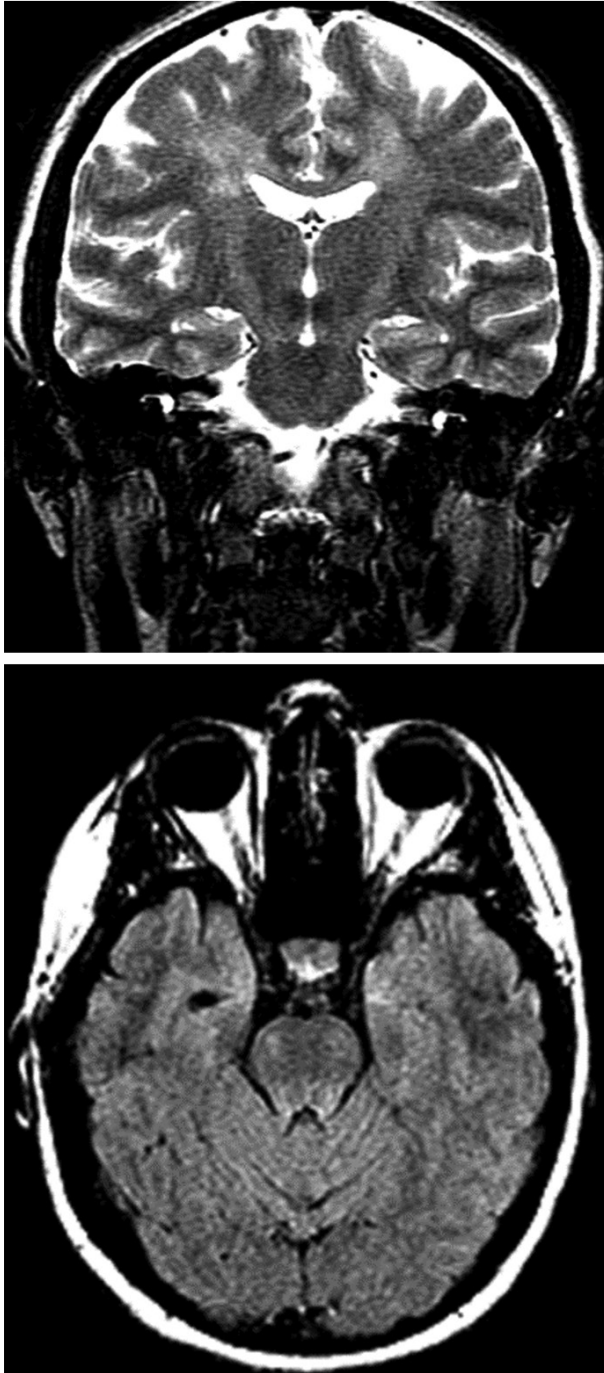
T2-weighted coronal (3a, top) and FLAIR axial (3b, bottom) MRI showing signal changes that reflect Wallerian degeneration in the corticospinal tracts (Courtesy Dr. Rita G. Bhatia).
